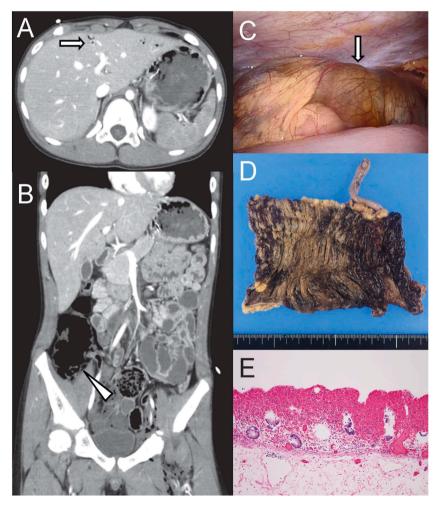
A, B. Representative contrast-enhanced CT demonstrating intrahepatic portal venous gas (A, arrow) and hypodense thickening of the ascending colon wall (B, arrowhead)
